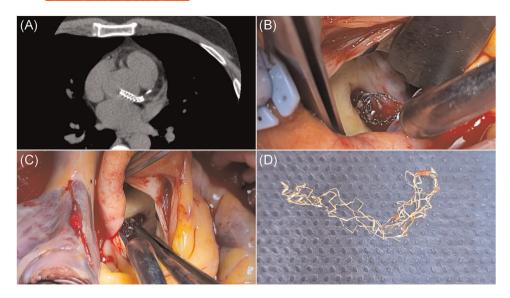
(A) Post-PCI angiographic computed tomography showing a dislodged left coronary stent into the aorta. (B) An aortotomy revealed the migrated coronary stent into the aortic lumen. (C, D) The dislodged stent was extracted from the left coronary ostium. PCI, percutaneous coronary intervention
